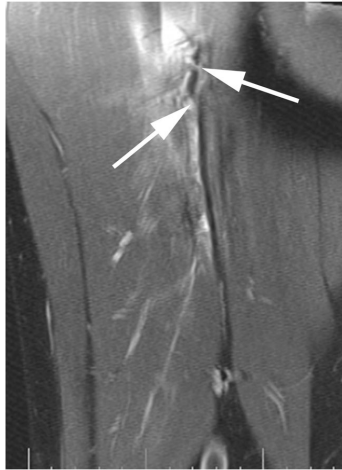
Coronal proton density-weighted fat-saturated MRI showing injury of the biceps femoris. There is diffuse peritendinous oedema and disruption of the central tendon (arrows). According to the modified Peetrons, this was scored as a grade 1 lesion (oedema only). According to the BAMIC, this injury was scored as a grade 3c lesion
